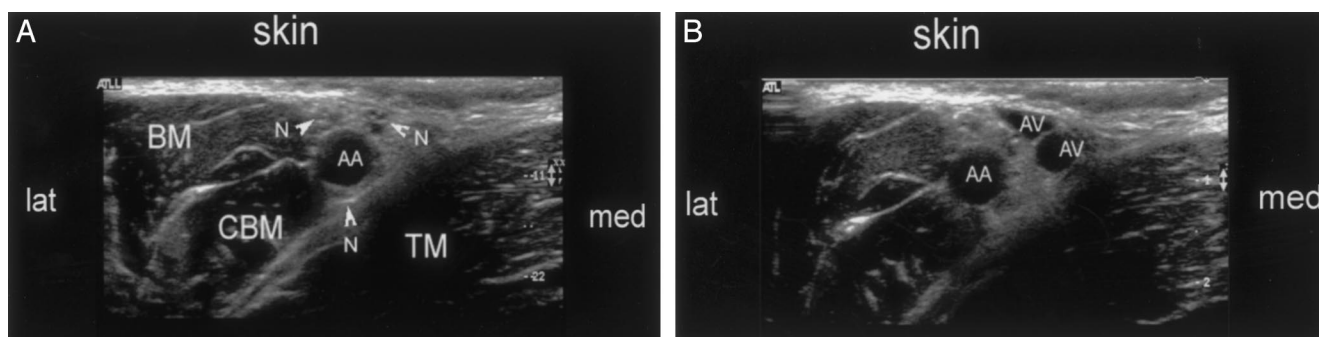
(A) Transverse sonogram in the axillary region showing three terminal branches of the brachial plexus as hypoechoic nodules (*N* with arrows). AA = axillary artery; BM = biceps muscle; CBM = coracobrachialis muscle; TM = triceps muscle. (B) Transverse sonogram in the axillary region showing axillary veins (AV) without compression.
